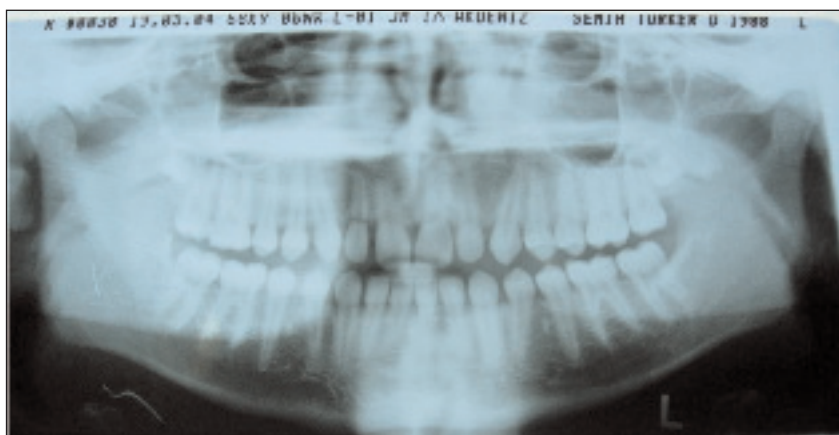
Panoramic radiograph showing root fractures of the upper right maxillary central and lateral incisors
